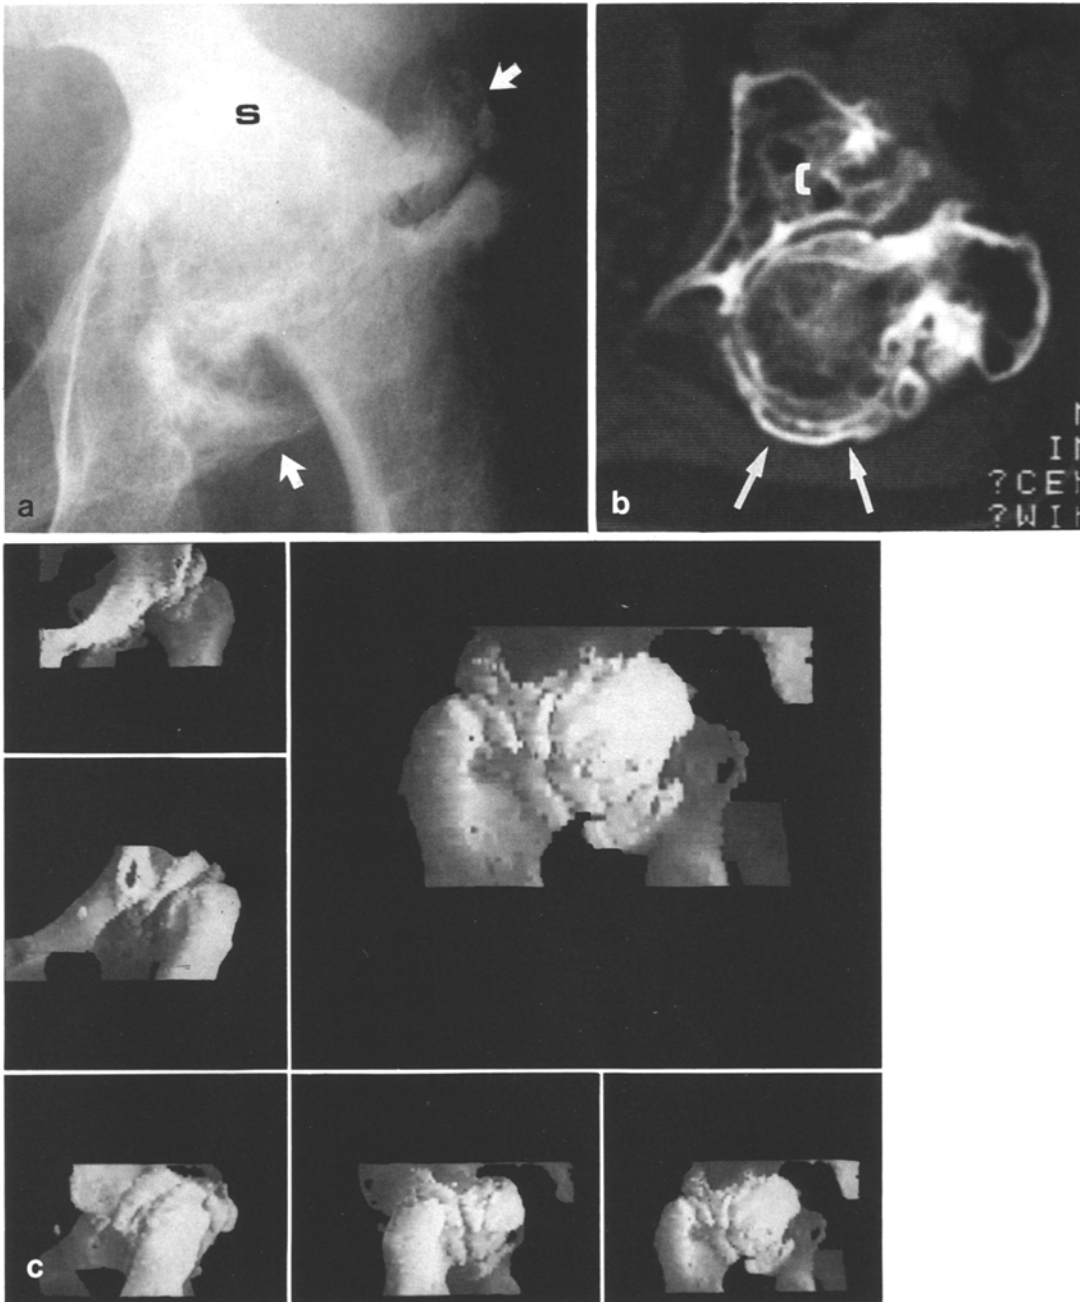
Chronic hip dislocation; a Conventional frontal radiograph of the left hip demonstrates obliteration of the joint space superiorly related to marked sclerosis [S] and cephalad migration of the femoral head. Prominent osteophytosis and fragmentation are also evident (*arrows*); b Axial CT image confirms the findings in a, but in addition reveals marked posterior subluxation of the femoral head. A thin rim of compensatory acetabular bone has formed posteriorly (*arrows*), and subchondral cysts (*c*) are also noted; c The abnormal femoral-acetabular relationship and secondary bony alterations are optimally depicted on 3D surface contour images
